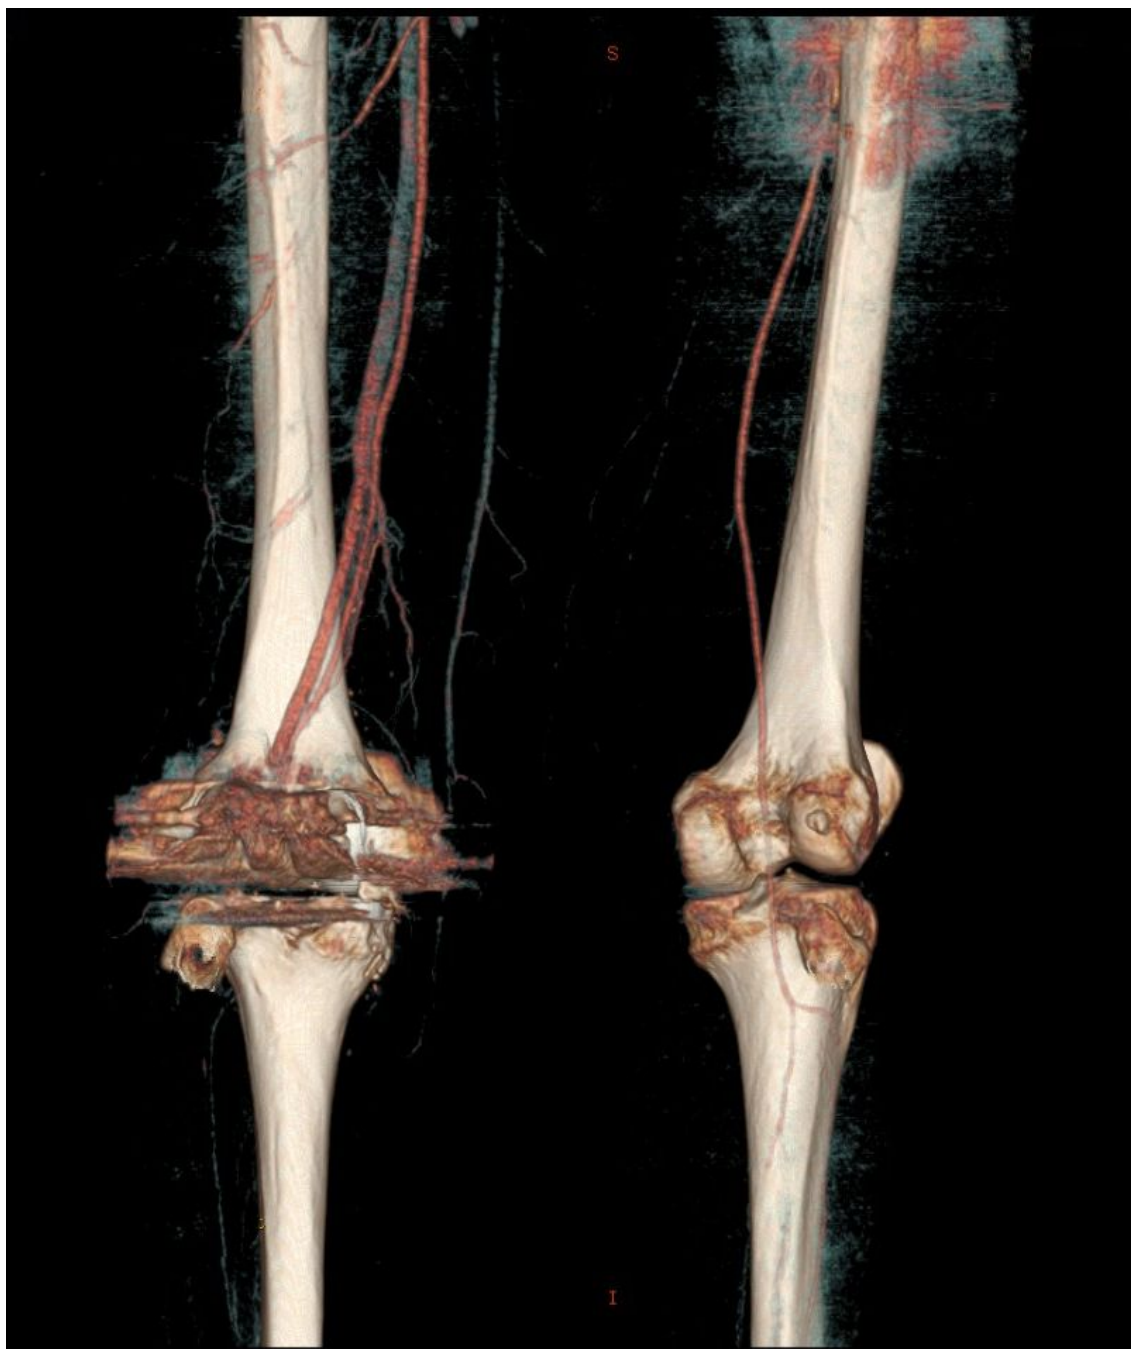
Multidetector computed tomography angiography – posterior view of the occluded popliteal Dacron graft.
